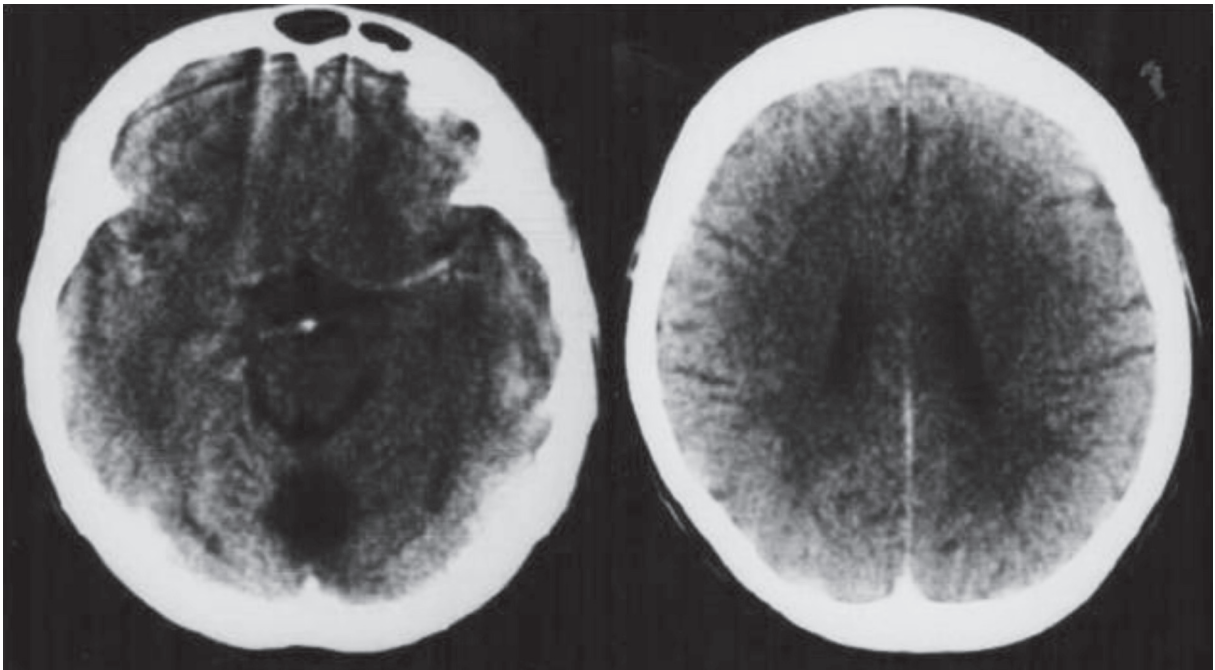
Postoperative computed tomography (CT) which performed after the first surgery in 1988. Note postoperative changes such as the area of encephalomalacia at the middle line of vermian.
